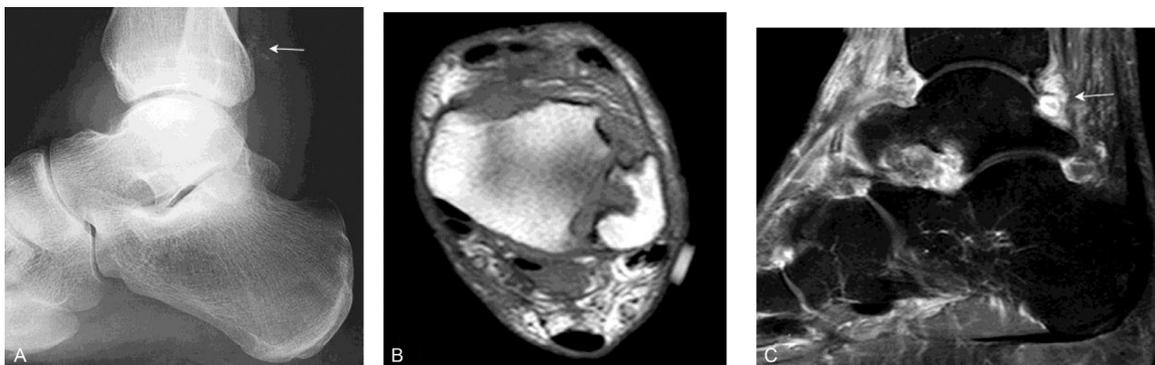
Primary synovial osteochondromatosis. (A) Lateral radiograph of the ankle shows a lobulated mass with calcification (white arrow). (B) Axial T1WI shows intra-articular iso intense lesions with bony erosions. (C) Sagittal postcontrast fat saturated T1WI demonstrates enhancement along the periphery of the lesions (white arrow). T1WI, T1-weighted images.
